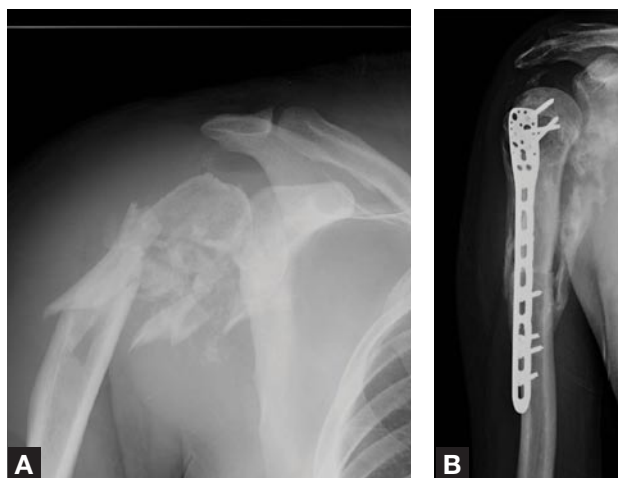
(A) Injury x-ray of another patient with a comminuted type IIIA proximal humerus fracture. (B) X-ray 17 months after surgery shows union across the host-allograft junction.
